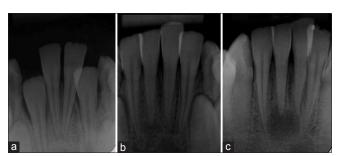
(a) Radiograph condition at initial examination after injury. (b) Evaluation at 26 months after luxation. (c) Radiograph evidence of pulp canal calcification and periradicular lesion
